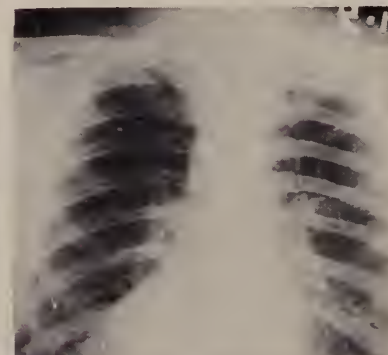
Case F. V. Radiograph of chest twenty-six days after admission. This patient had a temperature of 99 F. on the morning of his second hospital day; during the rest of his stay in the hospital, his temperature was not normal.
